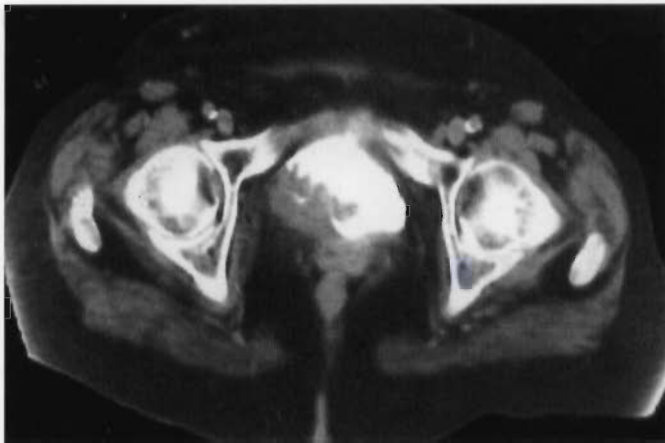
Pelvic CT-scan revealing a solid lesion deeply infiltrating the vesical wall.
